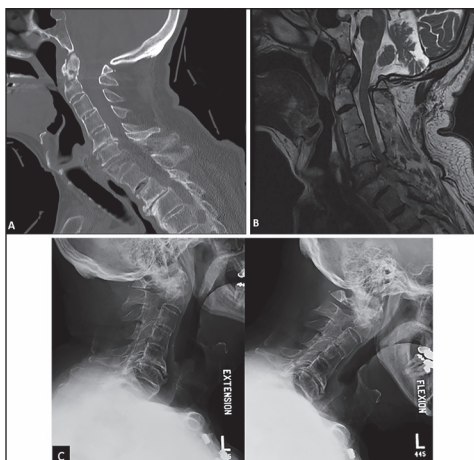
83-year-old male sustaining a C2 fracture. At the time of injury: (a) Sagittal computed tomography, (b) sagittal T2-weighted images demonstrating the fracture. (c) Flexion/extension X-ray 3 months after the injury demonstrating minimal movement at C2
